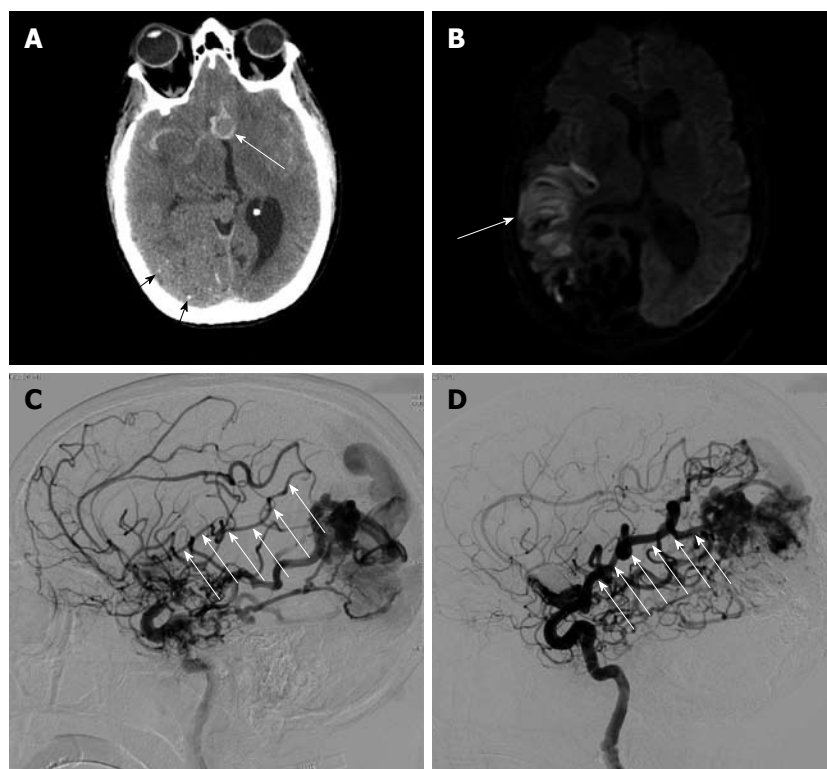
A 47-year-old woman with ruptured anterior communicating artery aneurysm associated with a large arteriovenous malformation. A: Computed tomography brain scan shows the 12 mm anterior communicating artery aneurysm in relief surrounded by high-density subarachnoid hemorrhage (white arrow). Also note small stippled calcifications in the large parietal-occipital arteriovenous malformation (black arrows); B: Diffusion-weighted magnetic resonance imaging shows area of restricted diffusion in the posterior right frontal lobe (white arrow) corresponding with the patient's left-sided weakness and hemi-neglect; C: Catheter arteriography of the right internal carotid artery in the lateral projection at the time of initial presentation approximately 1 wk following subarachnoid hemorrhage shows significant narrowing in the angular and Rolandic branches of the right middle cerebral artery, both of which supply the arteriovenous malformation (white arrows); D: Catheter arteriography of the right internal carotid artery in the lateral projection 4 mo after initial presentation and following complete neurological recovery shows resolution of vasospasm in the angular and parietal branches of the right middle cerebral artery supplying the arteriovenous malformation (white arrows).
